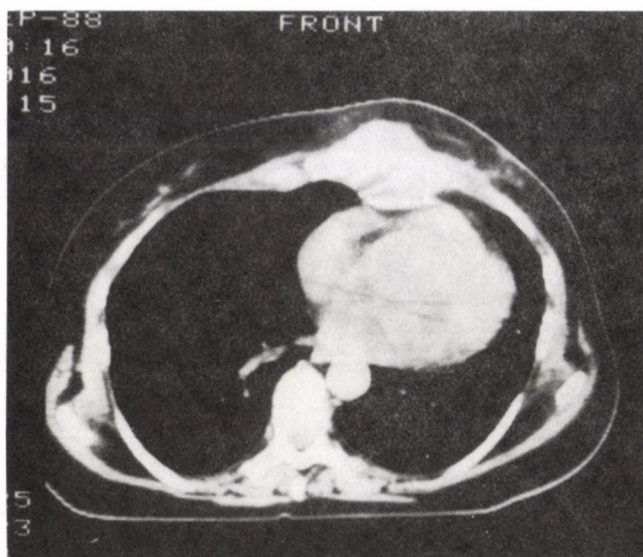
CT scan displays recurrent tumour in the left parasternal area following mastectomy. There is a small fat line between the intrathoracic part of the tumour and the pericardium, thus a gross tumorous infiltration of the pericardium is improbable
